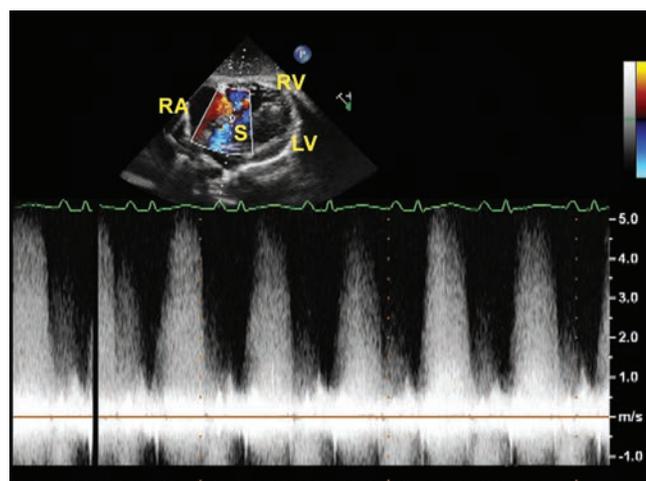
LV-RA/RV shunt (Gerbode shunt) visualized subcostally. CW Doppler shows a very high velocity over 5 m/s indicating a restrictive defect with no significant elevation of RV systolic pressure.
